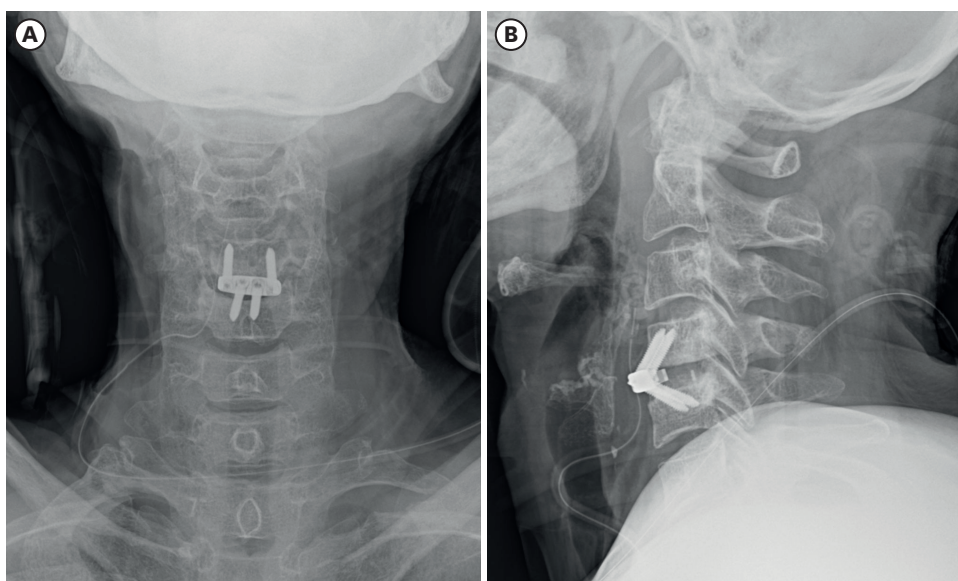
Postoperative cervical view is showing C4/5 anterior cervical discectomy and fusion with a ZERO-P spacer. (A) Anteroposterior and (B) lateral X-rays.
